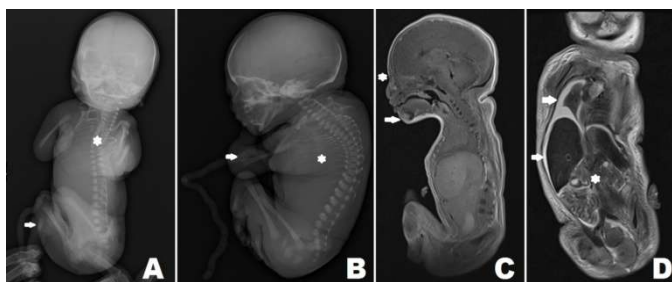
Fetus diagnosed as Ulbright - Hode Syndrome. Radiological Imaging was performed (plain radiographs and MRI on 1.5T scanner). A) Frontal radiograph showing scoliosis (*) and mesomelia in the lower limbs (arrow). B) Lateral radiograph showing long, slender ribs (*) and mesomelia in the upper limbs (arrow). C) T1 sagittal MR image showing craniofacial dysmorphism with micrognathia (arrow) and mildly depressed nasal bridge (*). D) T2 coronal MR image showing pleural effusion and ascites (arrows) and bilateral empty renal fossae (*).
